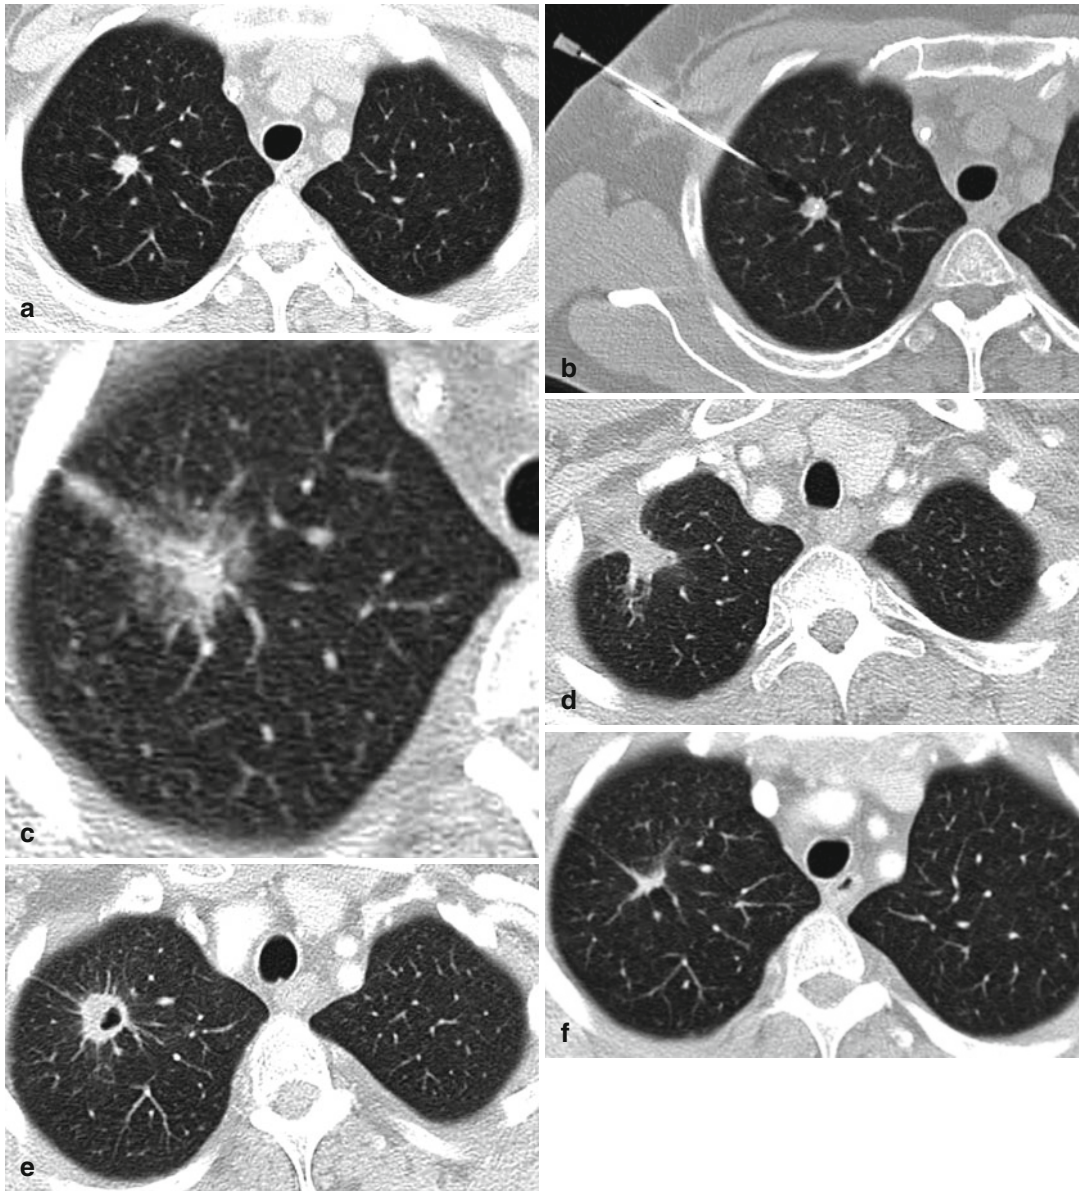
(a–f) RF ablation of a small NSCLC in the right upper lobe (a). Needle electrode placement using a tandem technique with a second needle for guiding the RF probe resulting in a central position of the enfolded tines (b). Post-ablation needle track hemorrhage and typical ground-glass opacification indicating a successful procedure (c). The control scan after 3 months shows enlargement of the treated tumor and thickening of the pleura in the region of the former needle entry site (d). On follow-up CT after 6 months, central cavitation can be differentiated (e). Follow-up CT 2 years after the ablation procedure reveals scar formation with no signs of local recurrence (f)
